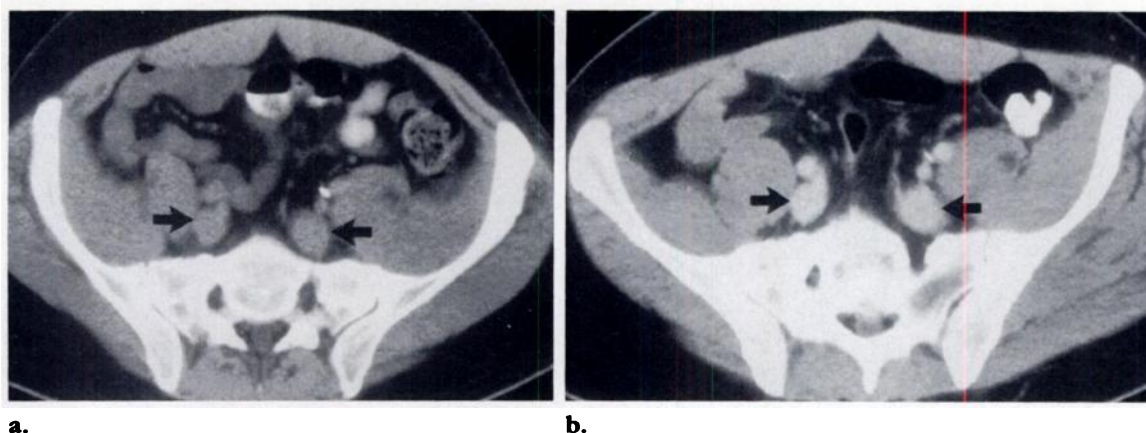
(a) Dynamic CT scan shows equivocal pelvic nodal enlargement (arrows). (b) Dynamic CT scan obtained at the same level after bolus injection of contrast material demonstrates that the suspected nodes are really prominent vascular structures (arrows).
